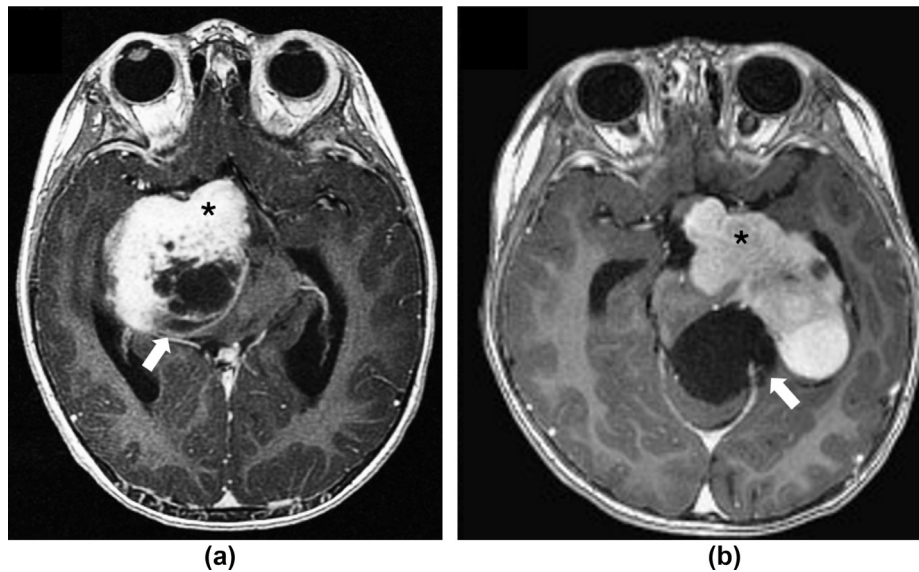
Two patients with pediatric optic pathway glioma (POPG) without initial leptomeningeal dissemination (LMD). (a) A 2-year-old boy with pilocytic astrocytoma. Axial post-contrast T1-weighted imaging revealed that more than 50% of the solid component of the tumor (asterisk) was asymmetrically positioned along the right visual pathway, with a well-defined tumor border, cystic changes (arrow), and heterogeneous enhancement. (b) A 2-year-old girl with pilocytic astrocytoma. Similarly, the POPG (asterisk) was asymmetrically positioned along the left visual pathway with a well-defined tumor border, cystic changes (arrow), and heterogeneous enhancement.
